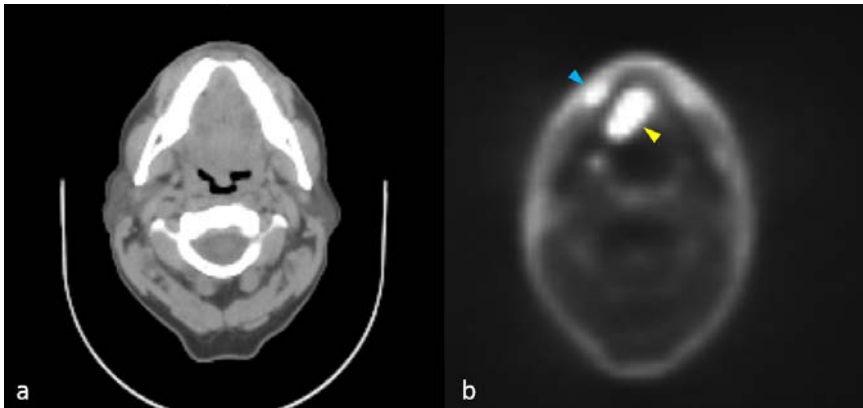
PET/CT images from the above patient shows hypermetabolic activity in the region ulceration (yellow arrowhead). A. CT is unremarkable. b. PET image of same level: Unexpectedly, increased metabolic activity was also seen along the buccal surface of the mandible (blue arrowhead). This lesion had extended submucosally across the gingival surface and was not clinically evident. Image courtesy of University of Massachusetts Medical School, Department of Radiology.
